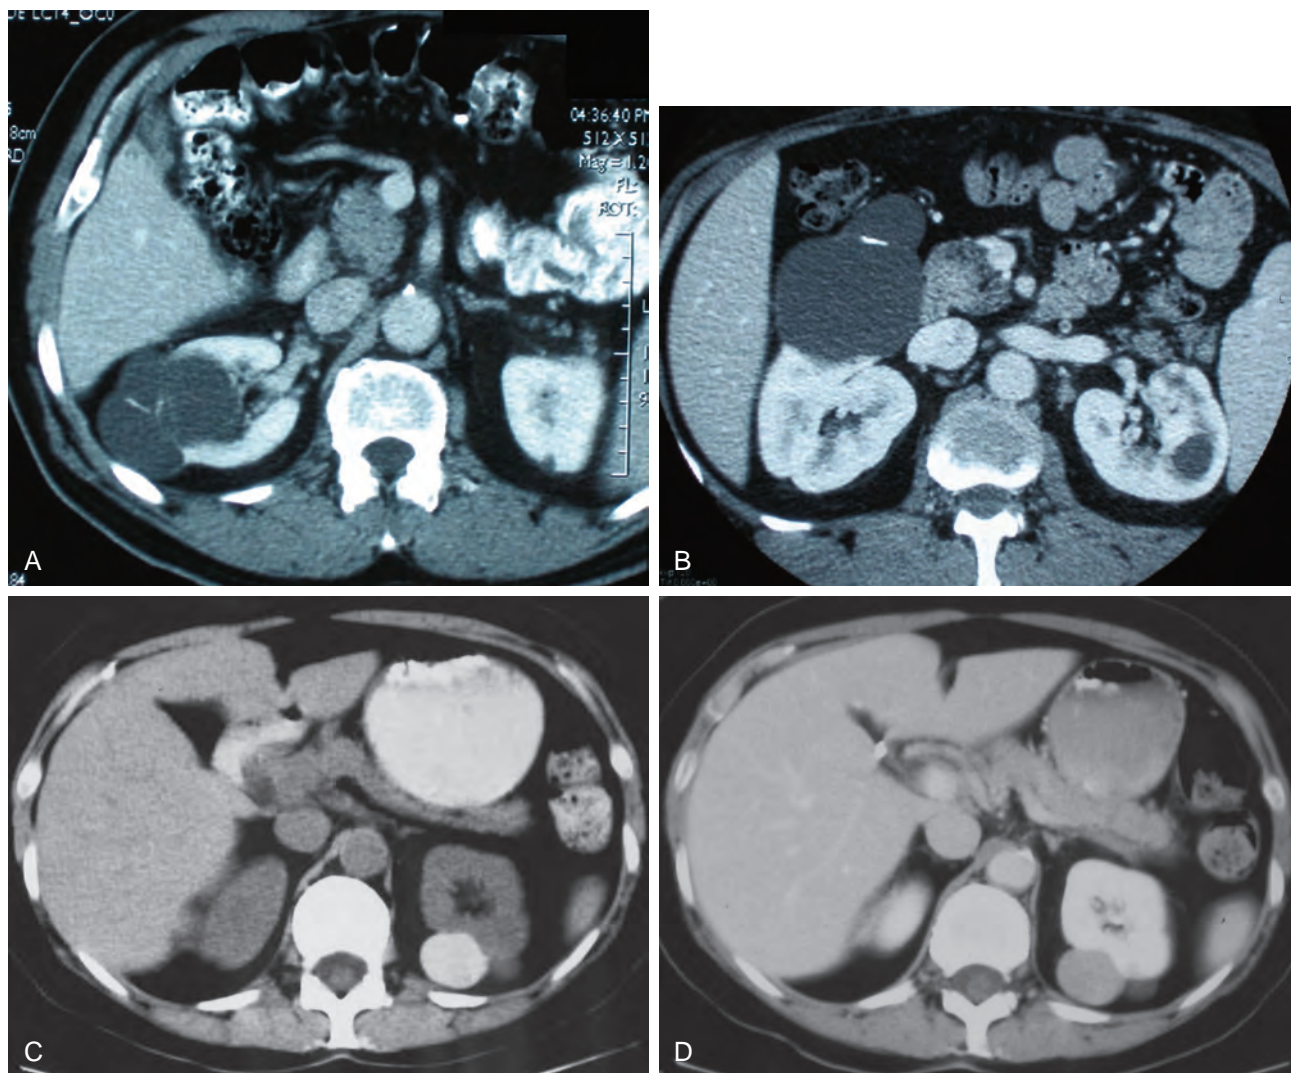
Bosniak category II renal cysts. A, Computed tomography (CT) scan shows right renal cyst with thin internal septation. B, CT scan in another patient shows relatively thin, curvilinear calcification in the septa of the wall of right renal cyst. C, CT scan without administration of contrast material shows small, smooth-walled, high-density left renal cyst. D, CT scan after administration of contrast material shows no enhancement of the cyst. This is an extreme example of a hyperdense cyst. (Courtesy Dr. Terrence Demos, Maywood, IL.)
